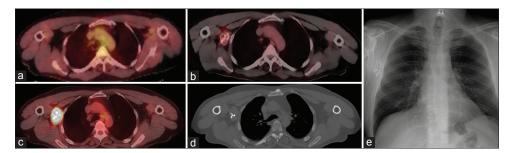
(a) Staging positron emission tomography/computed tomography not showing any axillary metastases, (b) Initial follow-up study showing a 18F-fluorodeoxyglucose avid (SUV = 4.4) right axillary mass around radiopaque foreign body, (c) Follow-up positron emission tomography/computed tomography done after 2 years showing intense activity in the right axillary mass (SUV = 14.4) and (d) showing linear wavy hyperdense foreign body in the center of the mass, and (e) X-ray chest revealing a wavy appearance of foreign body suggesting retained surgical sponge
